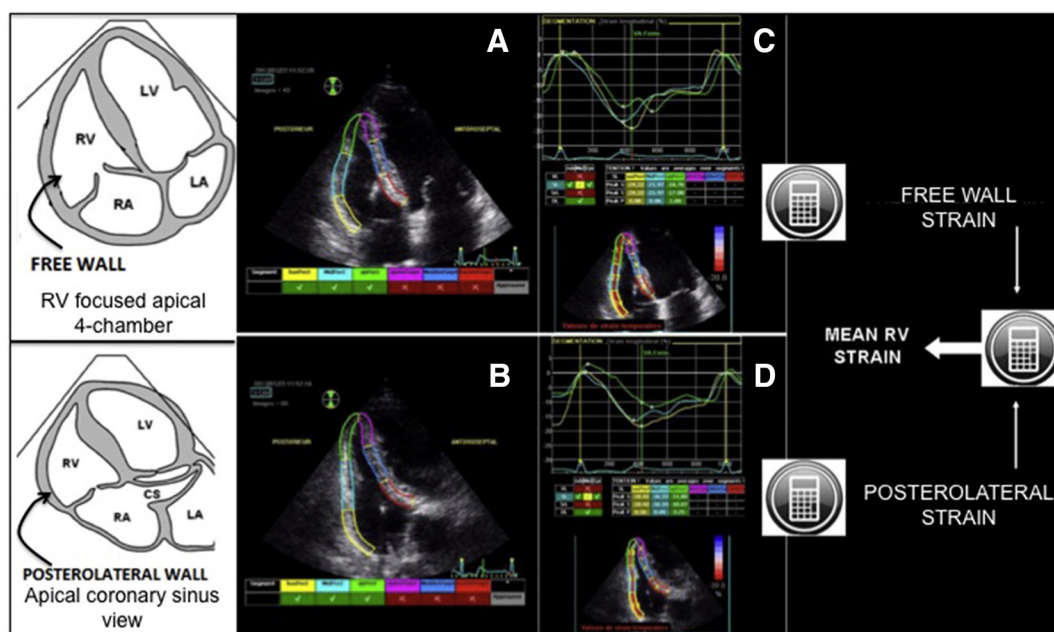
Calculation of mean RV strain. Storage of a RV focused apical 4-chamber view and an apical coronary sinus view as defined by the ASE guidelines [6]. Off-line analysis by tracking of a 6-segment region of interest with manually exclusion of the septal segments for RV free wall (A) and RV posterolateral wall (B). The software generated strain curves for RV free wall (C) and RV posterolateral wall (D). Mean RV strain was calculated manually by averaging strains from free wall segments and posterolateral wall segments.
